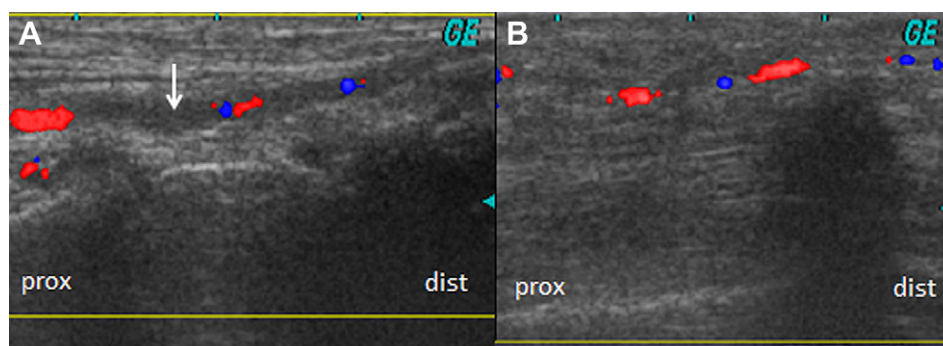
A 74-year-old woman with progressive systemic sclerosis developed gangrene on her left second and third toes. (A) Color Doppler ultrasonography of the left dorsalis pedis artery showing acute occlusion with thrombi (arrow). The artery is hypoechoic where the blood flow was disrupted. (B) Thromboangiitis obliterans (Buerger's disease). A 45-year-old man who was a heavy smoker suffered from bilateral fingers cyanosis, coldness, and pain. Color Doppler ultrasonography of the digital artery of the right second finger showing stenosis and decreased blood flow. The chronically occluded artery was not visible.
